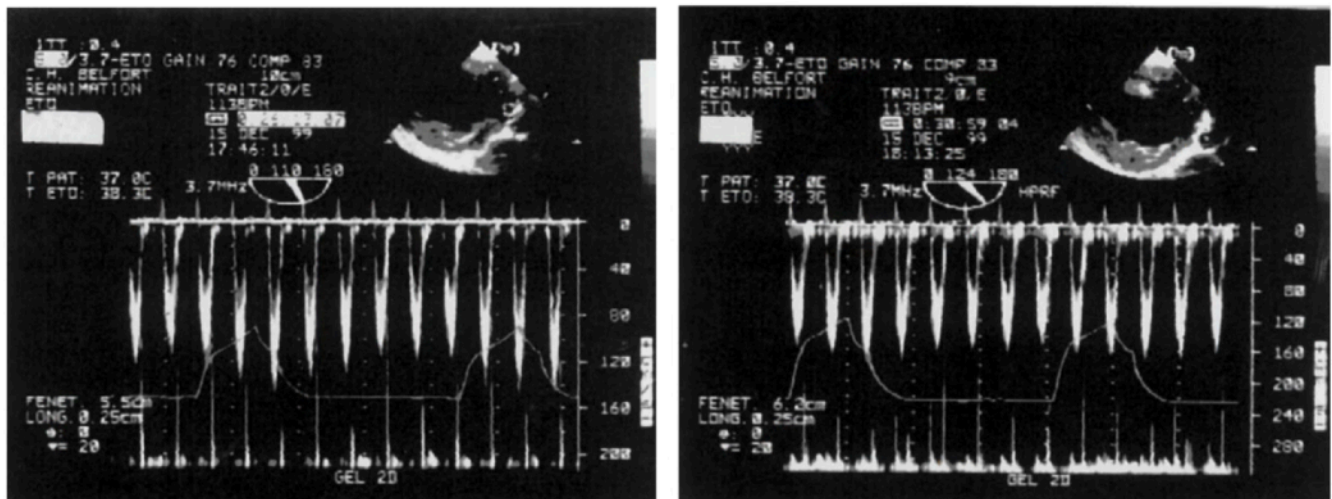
LVOT Doppler waveforms demonstrating variation in stroke volume before and after fluid administration.
